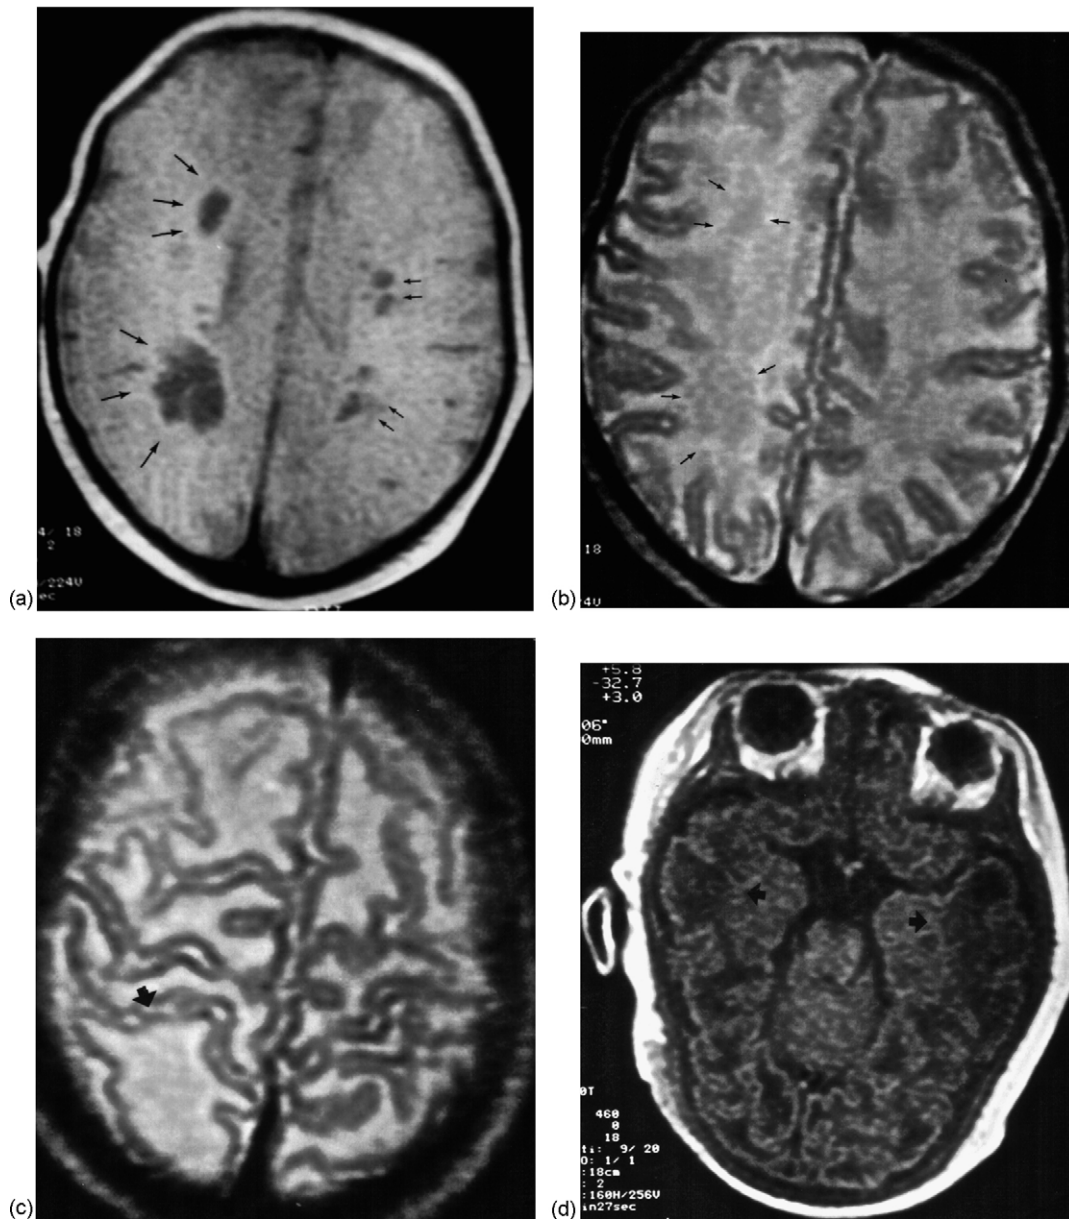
(a) T1-weighted MRI shows hypointense lesions in right corona radiata, centrum semiovale and retrotrigonal parieto-occipital deep white matter (arrows). (b) T2-weighted MRI shows isointense appearance of the lesions located on centrum semiovale and deep parietooccipital lesions (arrows). (c) T2-weighted MRI showing right occipitoparietal hyperintensity indicating edema (arrows). (d) T1-weighted MRI demonstrating bilateral hyperintense areas in the temporal regions (arrows).
